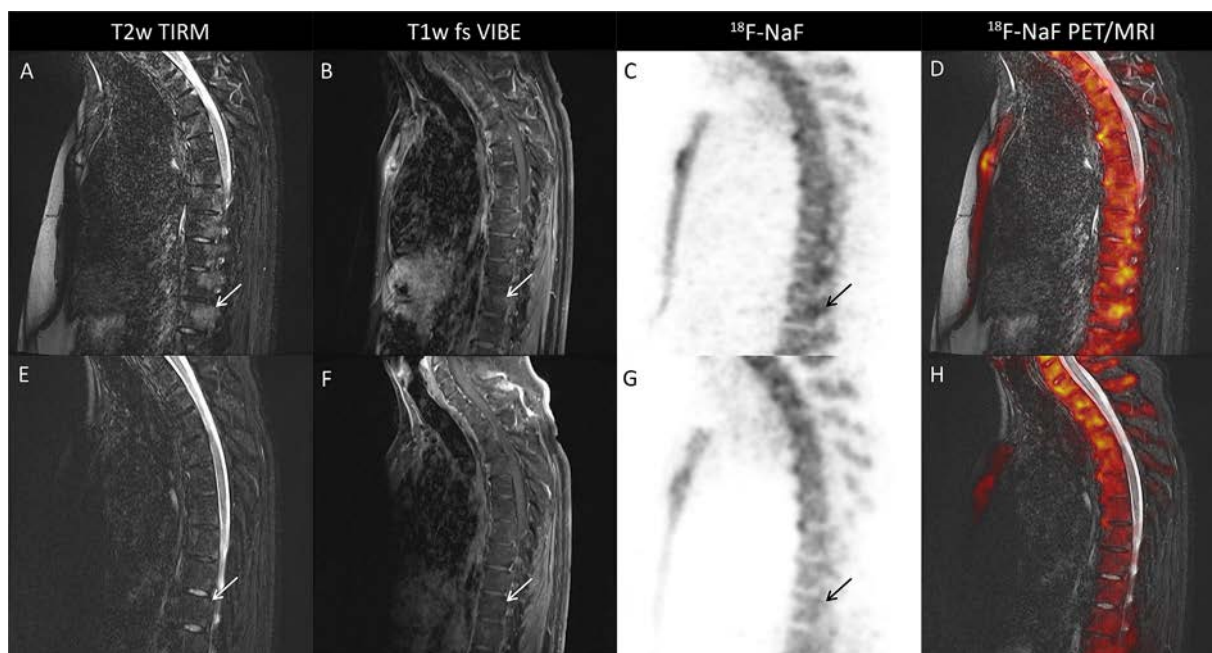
Findings of thoracic spine imaging at baseline (A–D) and follow-up (E–H) for a 40-year-old patient with clinically active radiographic axial spondyloarthritis. At baseline, signs of extensive bone edema are evident in the thoracic vertebral bodies (A and B; white arrows) with evidence of osteoblastic activity based on increased signal on fluorine 18-labeled NaF (^{18}F -NaF) PET/MRI (C and D; black arrow). Follow-up imaging after 4 months of tumor necrosis factor inhibitor treatment (E–H) showed visible decrease of inflammation and osteoblastic activity (white arrows, black arrow). T2w TIRM = T2-weighted turbo inversion recovery magnitude; T1w fs VIBE = T1-weighted volumetric interpolated breath-hold examination with fat suppression (see Figure 1 for other definitions).
